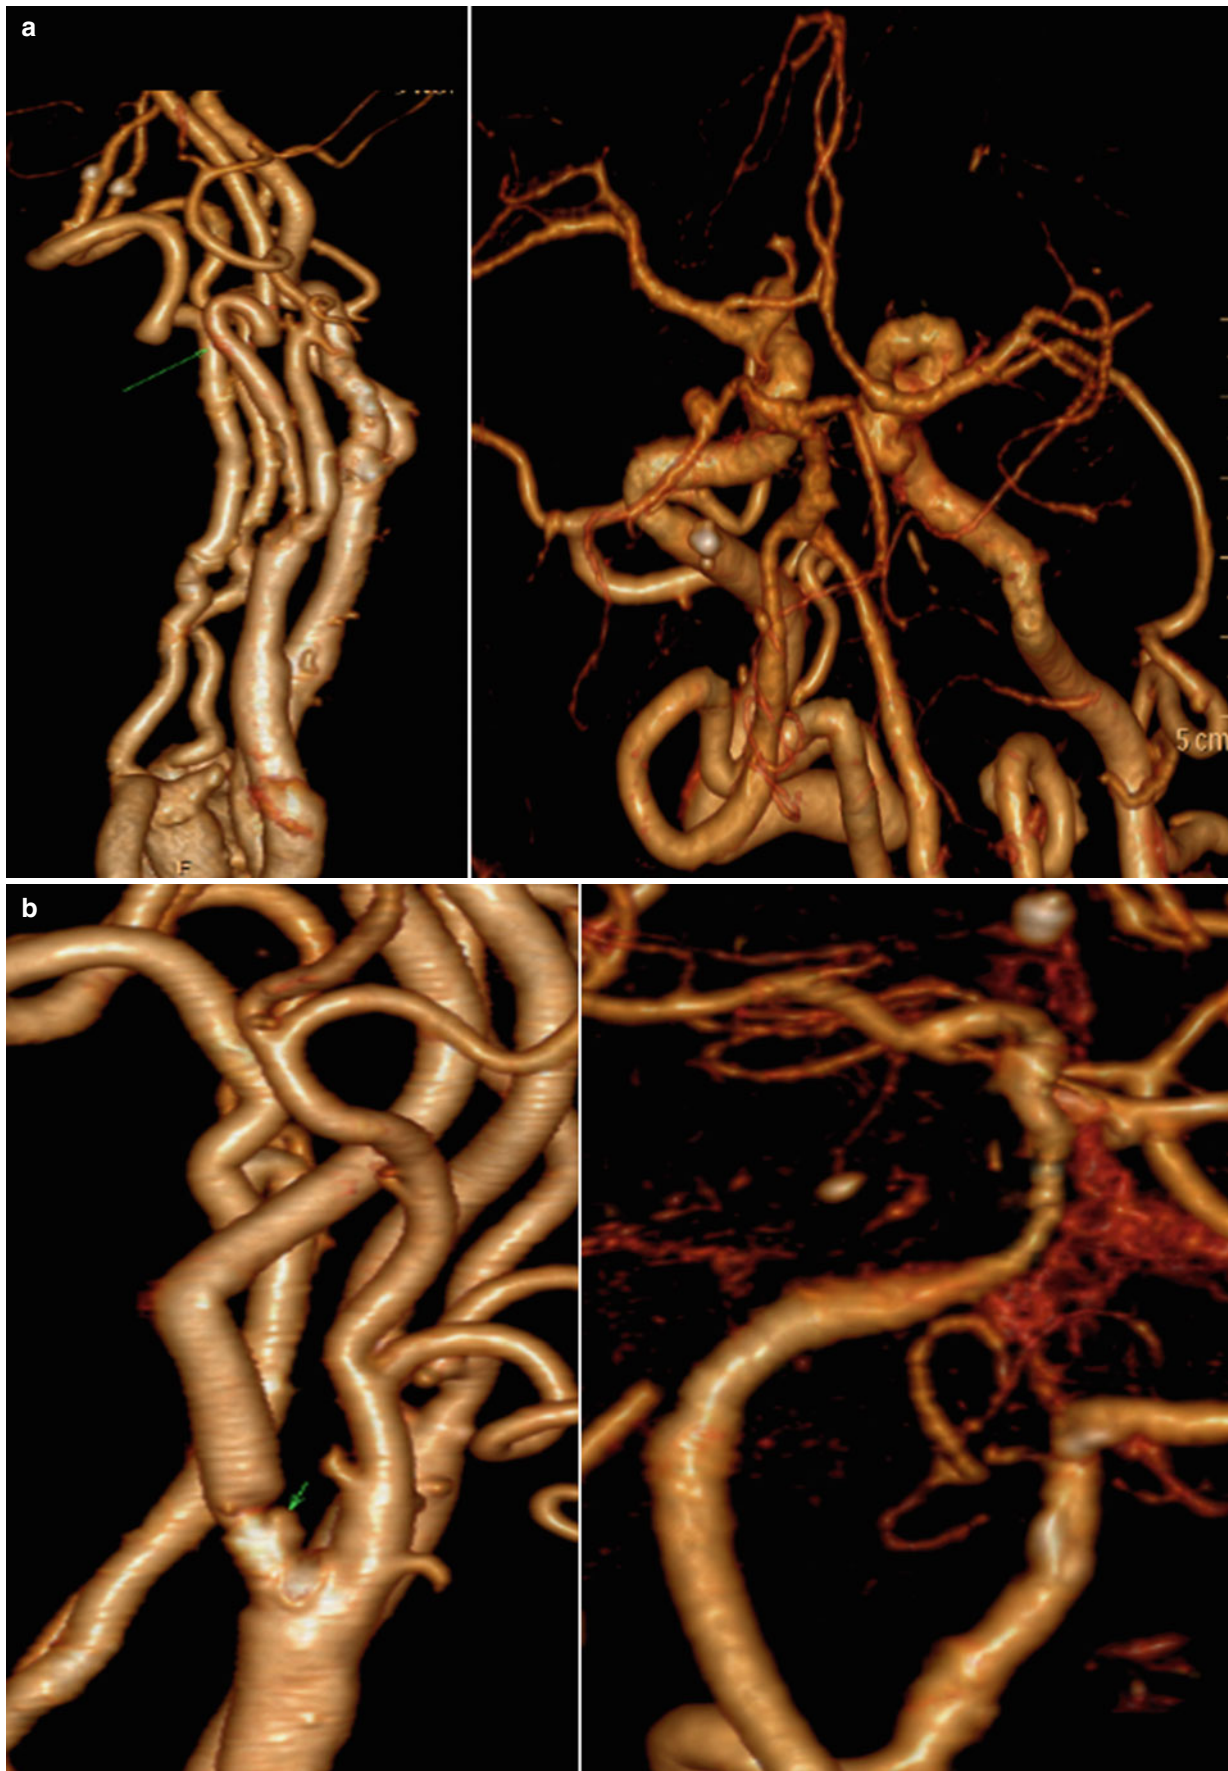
The CTA depicts a variety of additional abnormalities: loops, aneurysms, ulcers, and distal lesions in the ICA
